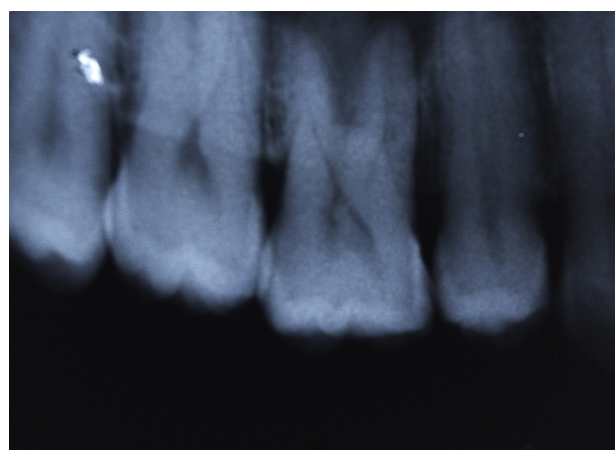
Intraoral periapical radiograph of 15,16 and 17 showing horizontal bone loss
